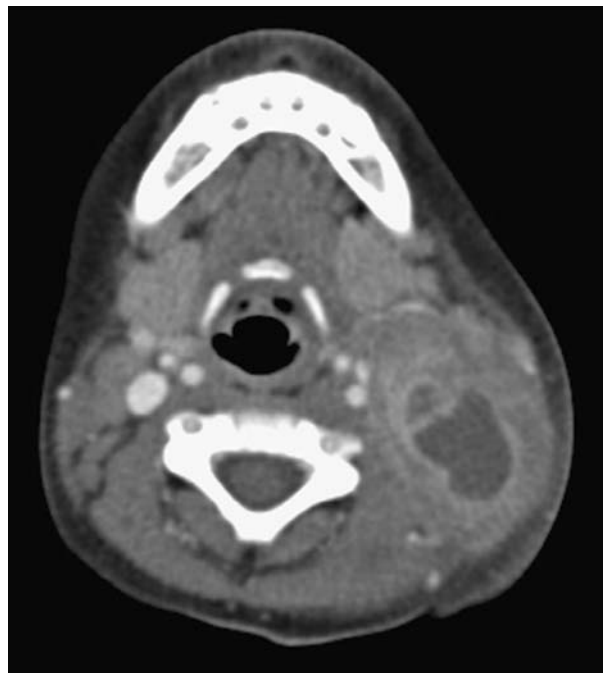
Computed tomographic scan with contrast demonstrating left lateral neck abscess/necrotic lymph nodes from cervical adenitis.
